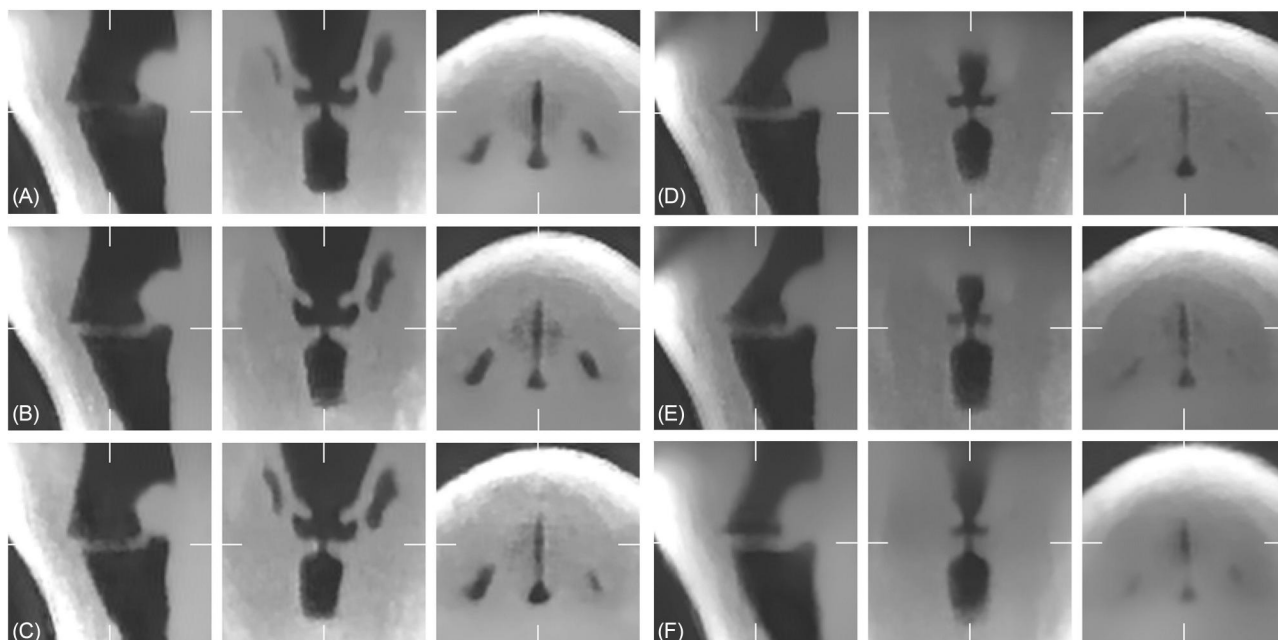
Sagittal, coronal, and axial views of 3D dynamic VF MRI for six distinct phonation conditions. Rows A–F correspond to the following configurations: *Stiff* (A), *Thin* (B), *Thick & VenF retract* (C), *Thick* (D), *Thick & AES narrow* (E), *Thick & VenF constrict* (F). Each column shows one anatomical plane (left to right: sagittal, coronal, axial). The crosshairs visible in each image indicate the corresponding plane positions in the other two dimensions, providing spatial orientation across views. The image shows the maximal open glottal configuration. A dynamic version is shown in the supplementary data (Traser *et al.*, 2026), video S2_slices animation.gif.
